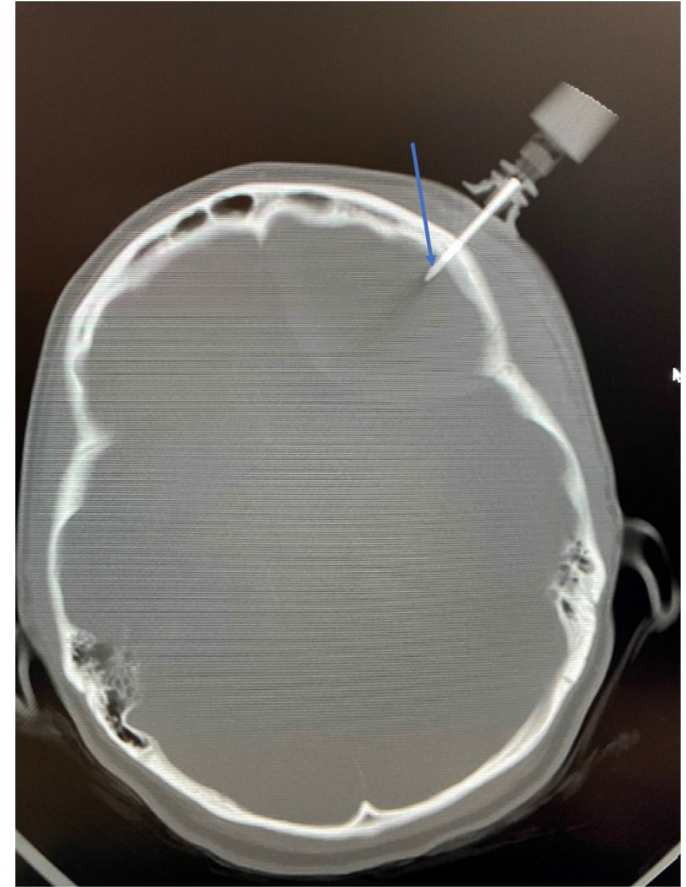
Computed tomography showing placement of emergent burr hole utilizing the EZ-IO® (arrow) into the left epidural hematoma.
